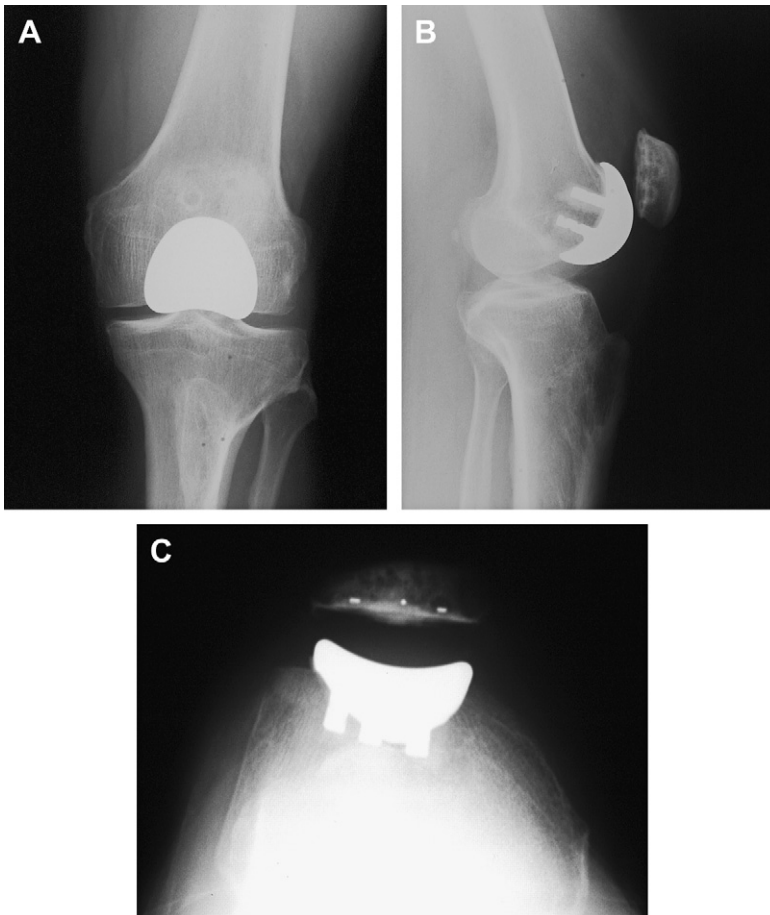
Postoperative (A) anteroposterior, (B) lateral, and (C) Merchant-view radiographs reveal proper position of the customized patellofemoral prosthesis. (From Sisto DJ, Sarin VK. Custom patellofemoral arthroplasty of the knee: surgical technique. *J Bone Joint Surg [Am]* 2007;89(Suppl 2, Part 2):223; with permission.)
